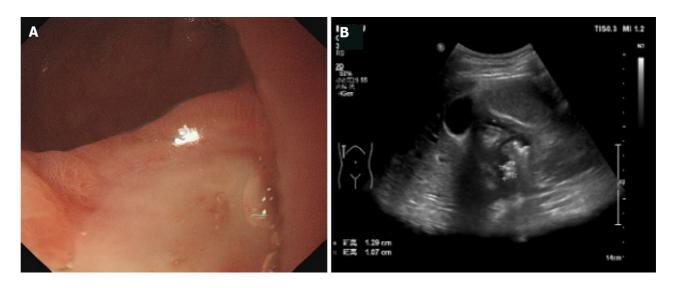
A 14-year-old male with duodenal ulcer diagnosed by gastroscopy. A: Gastroscope indicated a large ulcer on the anterior wall of the bulb, covered with thick white moss, congestion and edema of the surrounding mucosa; B: Contrast-enhanced ultrasonography showed that the shape of duodenal bulb was irregular, the area was small, and there were hyperechoic plaques, 13 mm × 11 mm × 13 mm in size, on the anterior wall of the duodenum.
